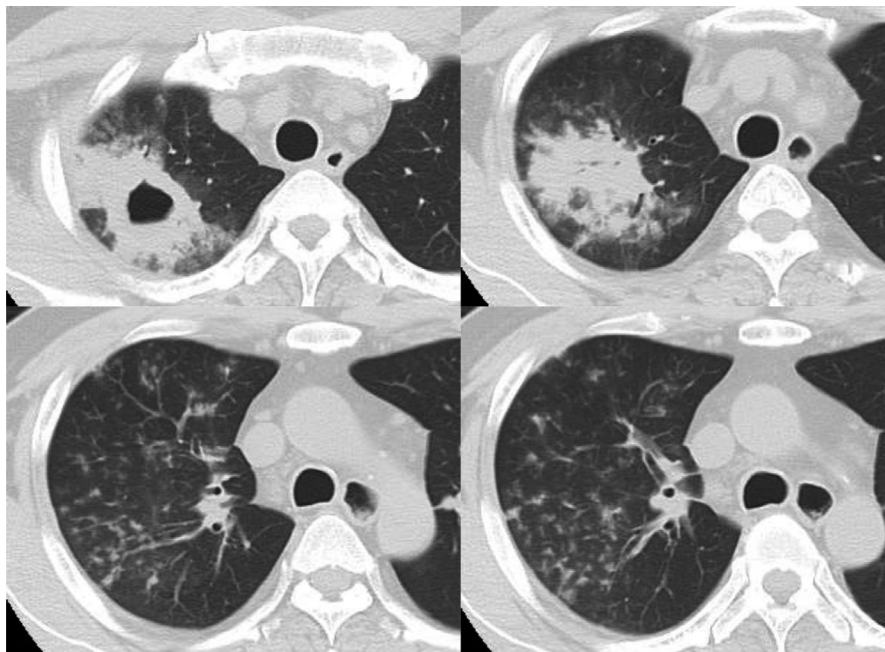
Computed tomography findings of the chest. Consolidation, thick-walled cavity (lung abscess), and multiple small nodules indicating a tree-in-bud appearance were observed in the right upper lobe. These findings suggest pulmonary tuberculosis
